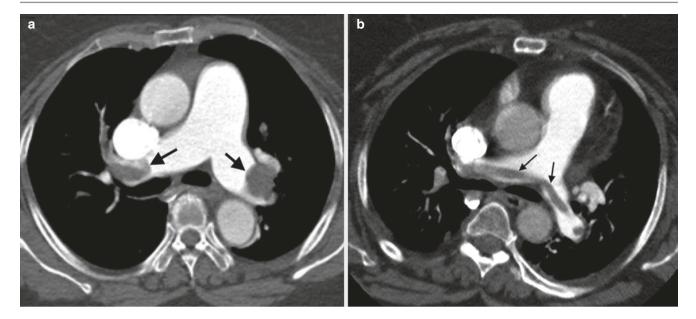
CT pulmonary angiography. A - Thrombus occluding right and left pulmonary arteries (arrows). B - Saddle embolus (arrows)
